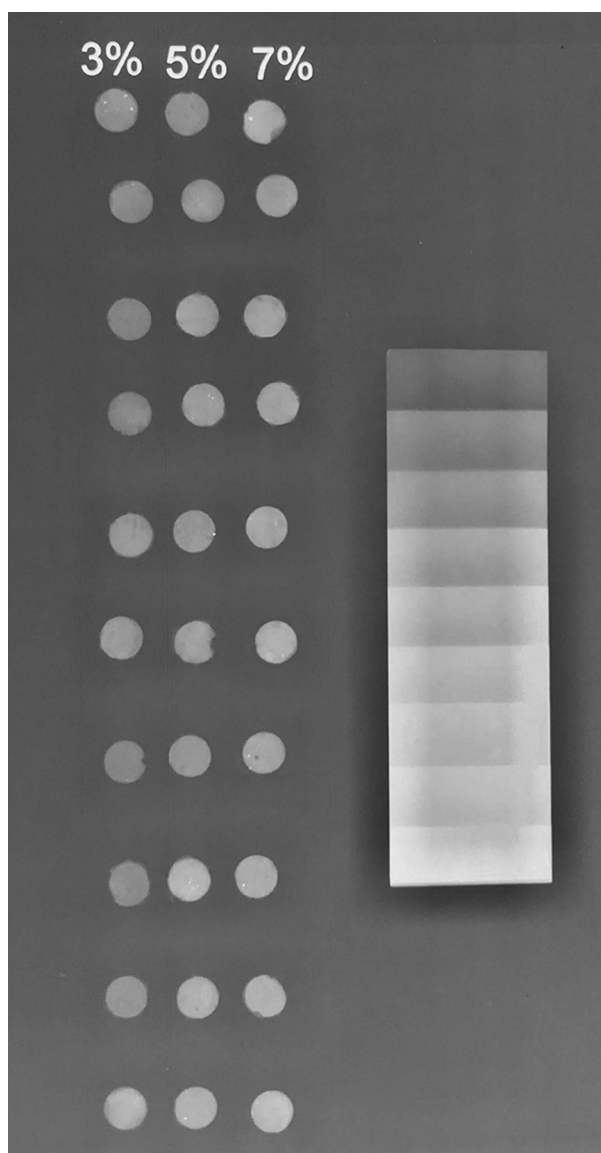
Digital radiograph of samples and an aluminum step wedge that was graduated from 1 mm to 9 mm thick. In the powder constituents, 3 different concentrations of Bi_2O_3 were used: 3%, 5%, and 7%. Discs of the material (10 mm diameter and 1.0 mm height) were prepared for each concentration. An X-ray machine operating at 65 kV, 10 mA was used to produce an image on a phosphorus plate film. The mean of 10 samples of each concentration of Bi_2O_3 was taken as the density of the material and was compared with the density of the aluminum step wedge using an optical densitometer (Table 1).
